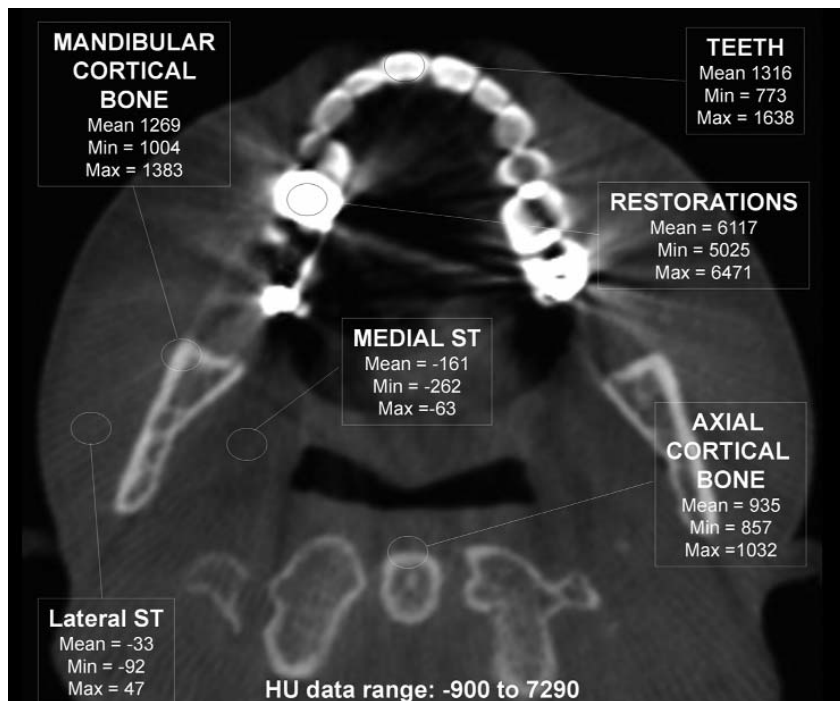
Mean, minimum (min) and maximum (max) grayscale values measured for specific tissues in an axial CBCT scan. Note the large range in grayscale measurements in relatively homogeneous tissues. These values are not calibrated to water as in conventional CT measurements and should not be referred to as Hounsfield Units.
